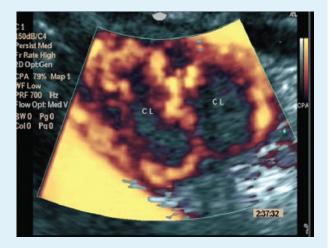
Doppler image of ovary with two corpora lutea (CL). Image courtesy of Simon Meagher, Monash Ultrasound for Women, Melbourne, Victoria, Australia
